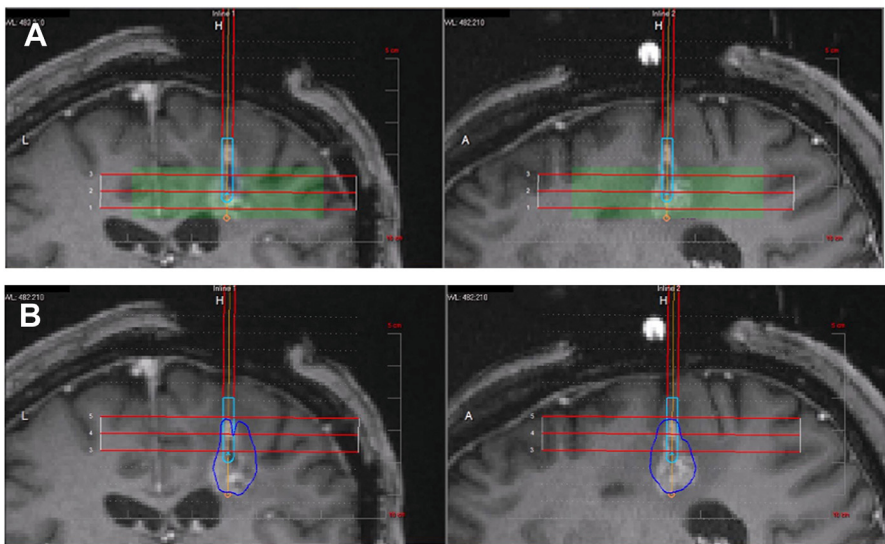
MRI-guided LITT-based ablation of a recurrent left frontoparietal GBM. (A) Coronal and sagittal T1-weighted images after gadolinium administration showing placement of the electrode in the region of contrast enhancement. (B) Real-time MRI measurement of the area of the tumor receiving the therapeutic thermal coagulation (blue line).
